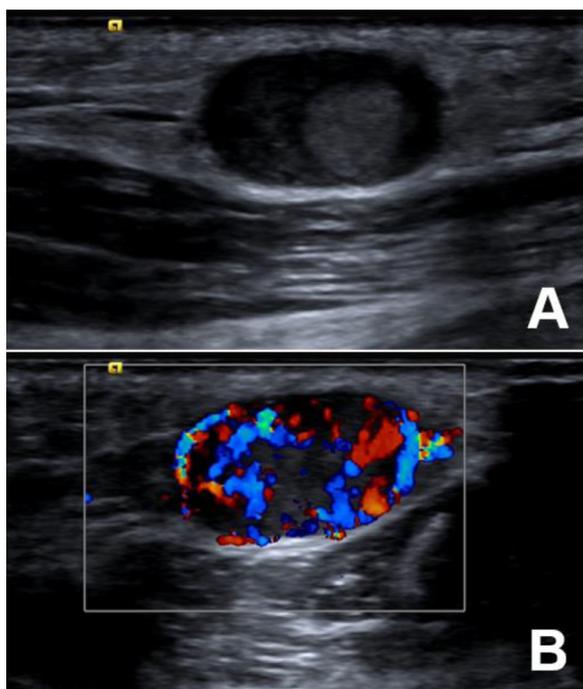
(A) Superficial ultrasound of the right arm shows an oval, hypo-echoic nodule with well-defined margins and no shadowing in the subcutaneous fat. (B) Extensive vascularity is noted.
